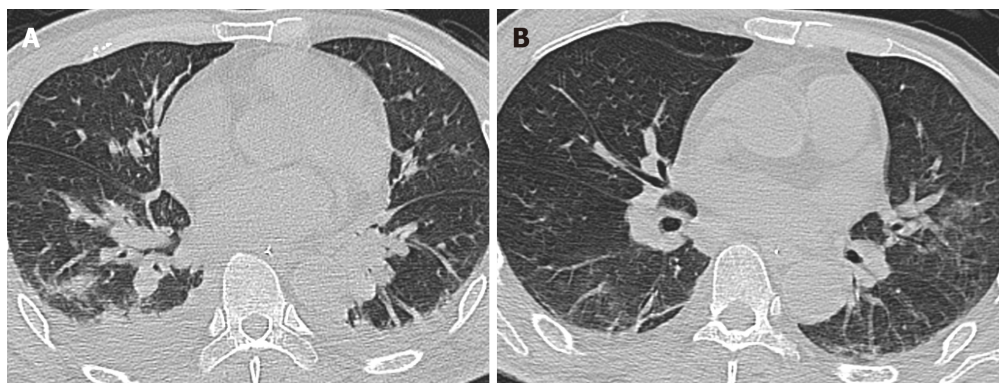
Findings of chest computed tomography. A: Three weeks before the patient was transferred to our hospital, chest computed tomography showed pulmonary consolidation and pleural effusion; B: Upon admission to our hospital, chest computed tomography showed that pulmonary infection had alleviated, but some inflammatory infiltrations were present.
